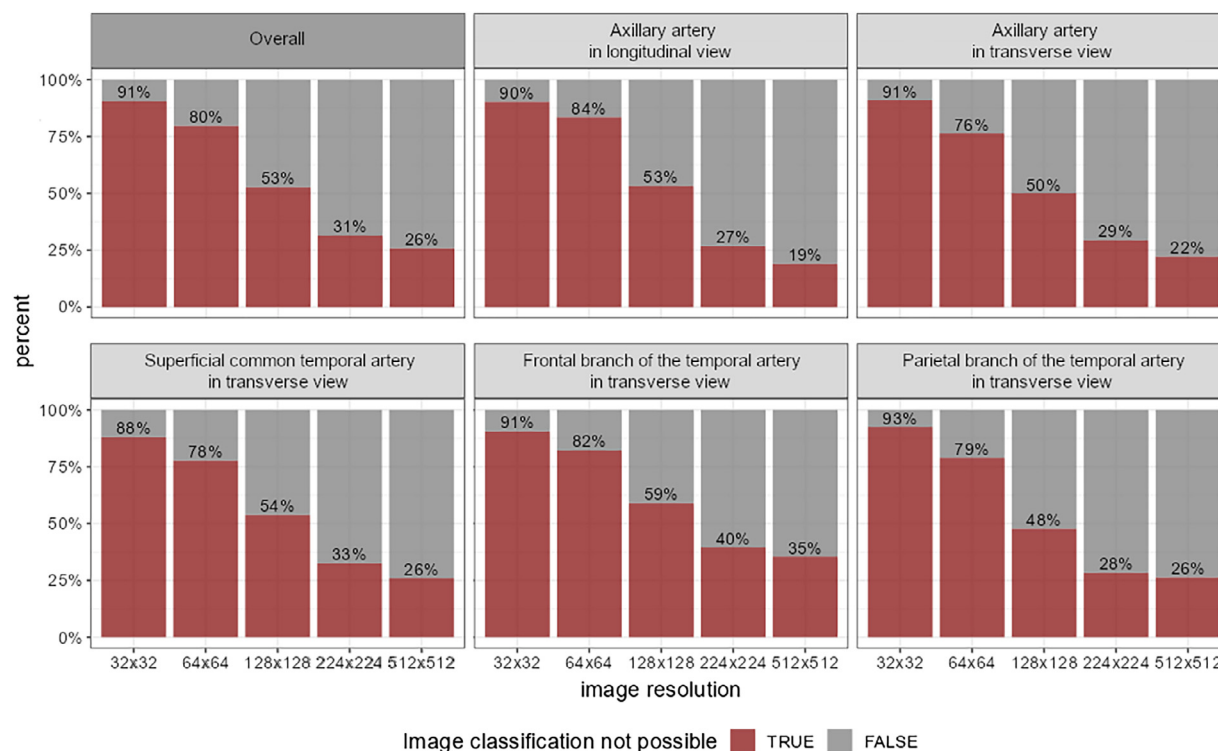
Frequency of the response option ‘Meaningful classification is not possible’ being selected during vascular ultrasound image classification, depending on the respective artery (and view) and image resolution. For all arteries, the frequency of this response option being selected decreased with increasing image resolution (consistent with every sequential stage of increased image resolution).
